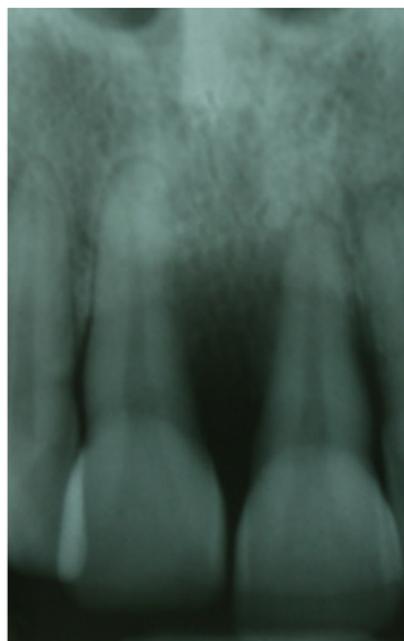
Figure N 12b: Case Report n. 2 Periapical Rx after 1 year.
